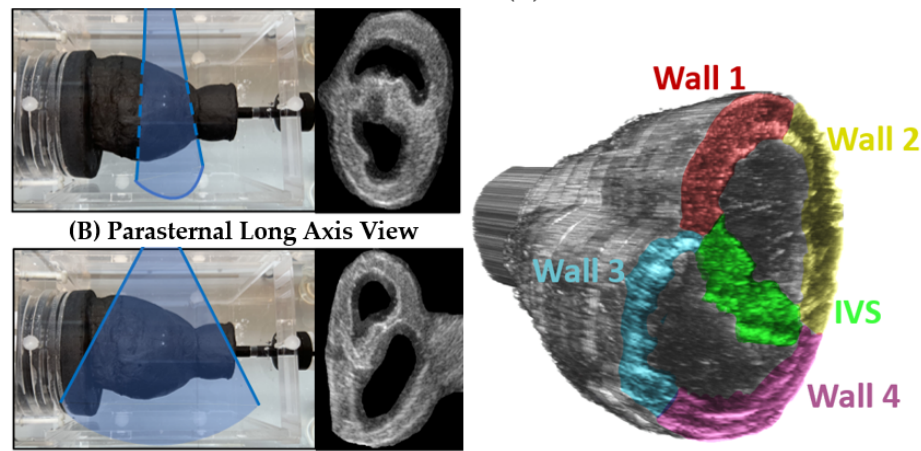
Two DHP-based views used for acquiring data. (A) (Left-Right) Using a Philips P4-1 transducer, imaging data is acquired in the parasternal long axis (PSLA) view. The right image shows the corresponding B-mode image. (B) (Left-Right) Upon rotation of the transducer by 90 degrees, the parasternal short axis (PSSA) view is acquired. The image on the right is the corresponding B-mode image. (C) 3D rendering of multiple slices of acquired B-mode ultrasound imaging data using a computer-controlled motion stage in the elevation direction. The investigated wall segments and the IVS are indicated in color.
